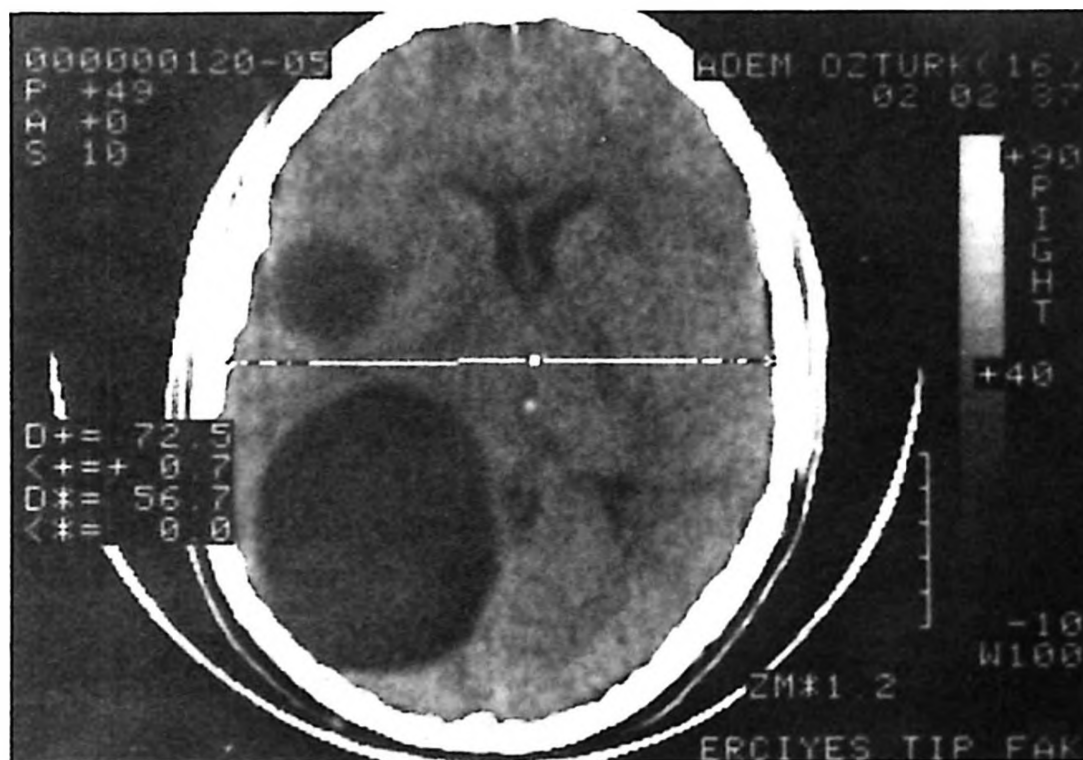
Follow-up CT scan seven months later showing a large recurrent cyst in the operated area and extremely rapid growth of the small cyst seen in the first scan.
